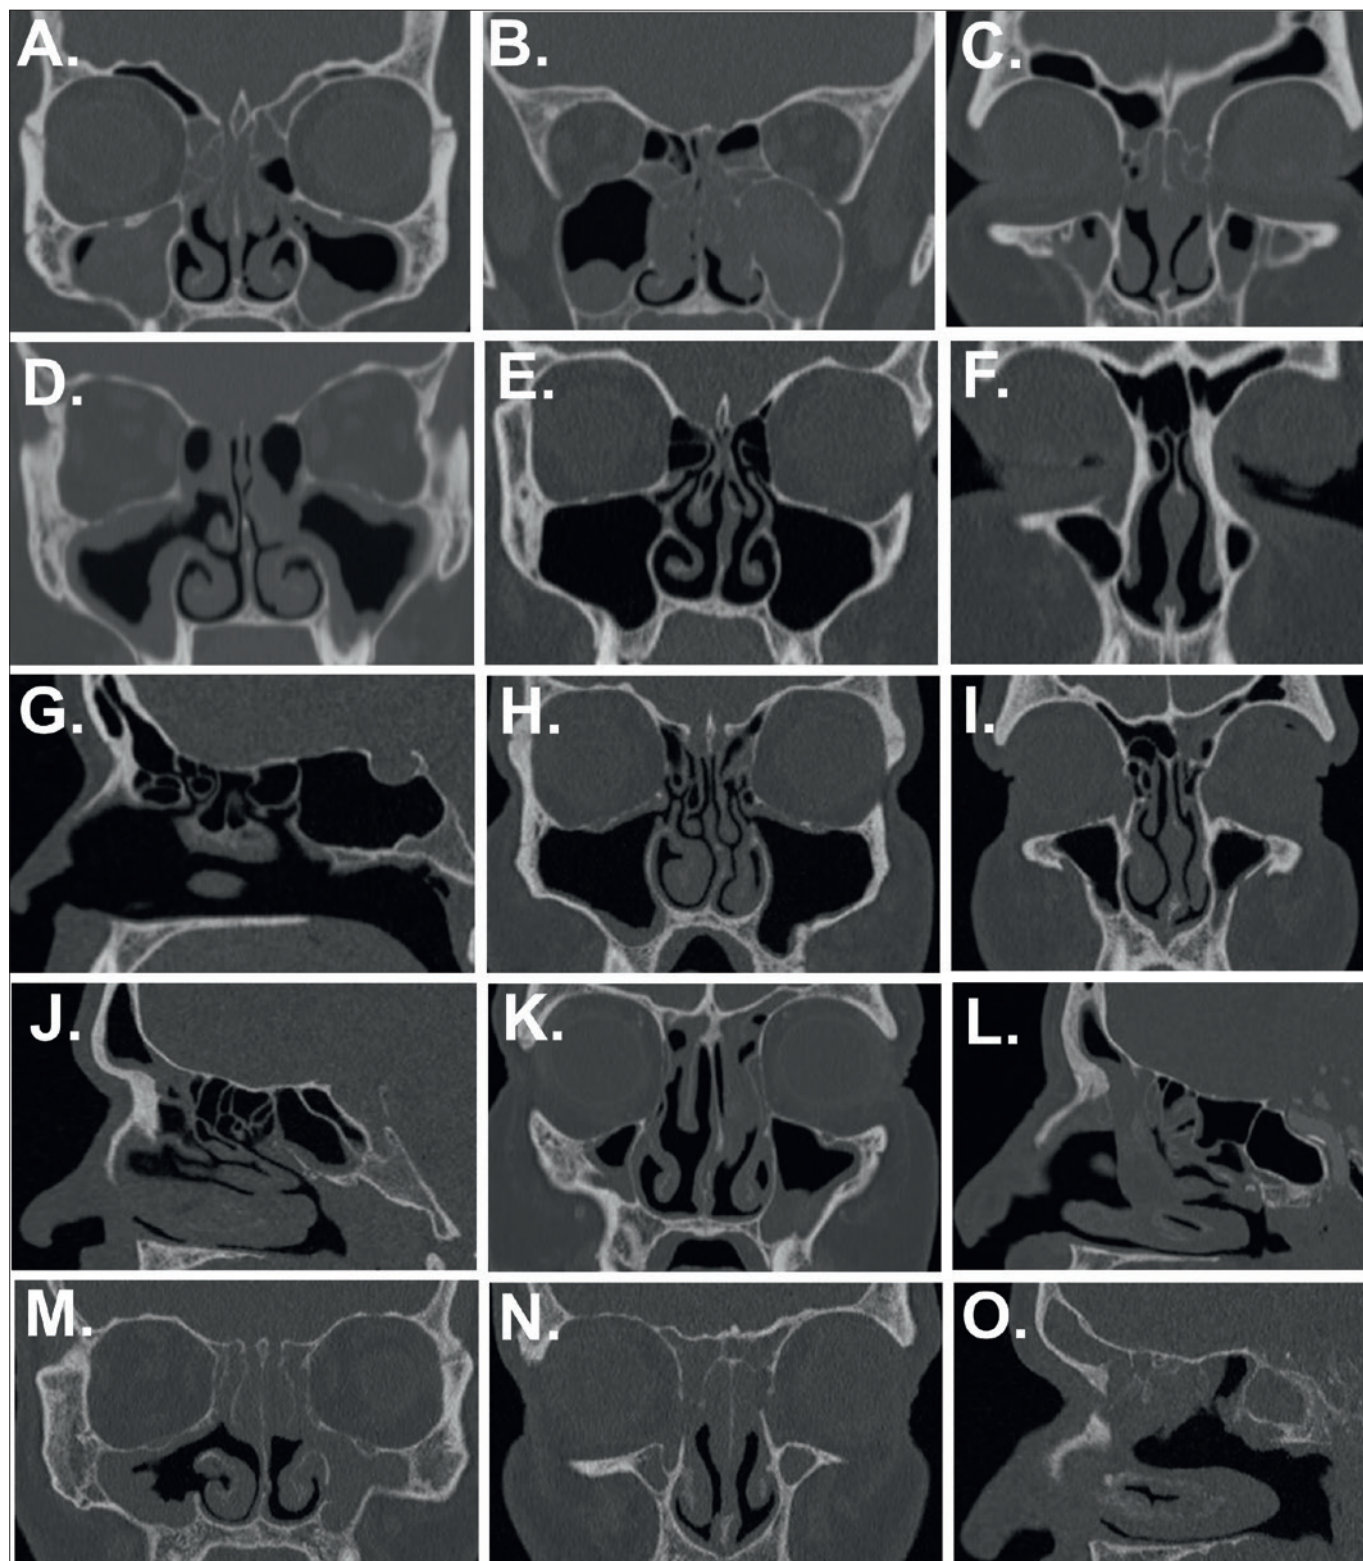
Examples of radiologic signs that were evaluated from sinus computed tomography (CT) scans, which were routinely performed due to clinical purposes. (A) Anatomical fine structures of middle turbinates are not detectable. (B) Middle and inferior turbinates are not detectable. (C) Obstructed frontal recess on both sides. (D) Signs of previous operation (middle meatal antrostomy on both sides) and undetectable left middle turbinate. The reasons for “not detectable” responses were poor visualisation of middle turbinate due to polypoid change or operative modification of turbinate. (E-G) Example of a patient with RS 0 score. (H-J) Example of a patient with RS 1 score. (K-L) Example of a patient with RS 2 score. (M-O) Example of a patient with RS 3 score.
